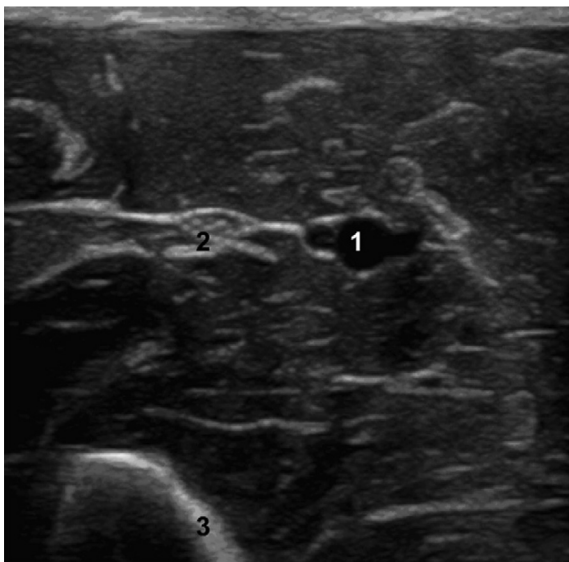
Transverse ultrasound image at mid-forearm level demonstrating the dark, anechoic ulnar artery (1), hyperechoic or 'honeycomb' appearance of the ulnar nerve (2) and bright, hyperechoic bony outline of the ulna (3).
